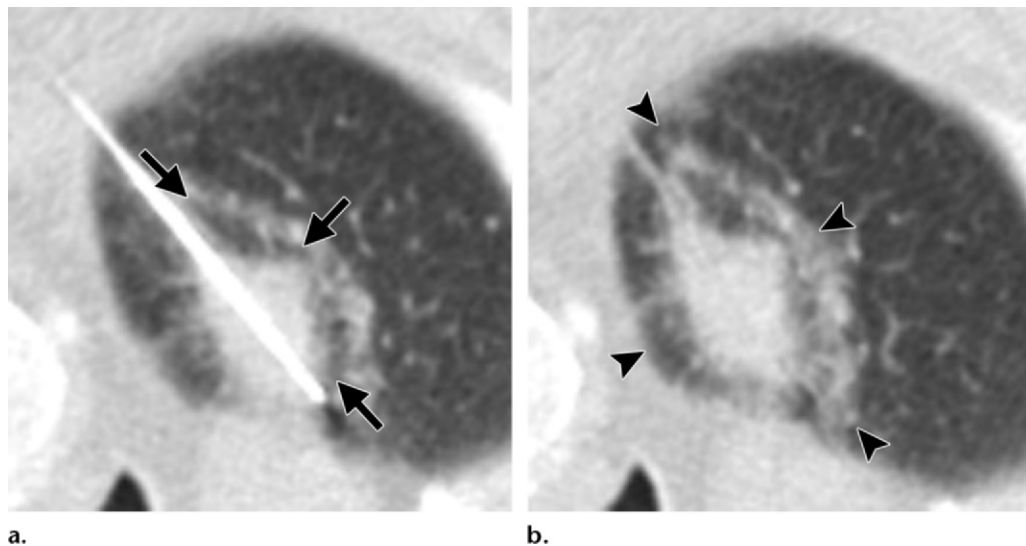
Metastatic ependymoma in a 58-year-old man undergoing RFA with a single probe. (a) CT image obtained at completion of the ablation cycle shows increased attenuation around the probe and the lesion, a finding referred to as the lightbulb sign (arrows). (b) CT image obtained immediately after ablation and removal of the probe shows an area of cone-shaped sectorial hyperemia (arrowheads), a finding that corresponds to the safety zone, the area of ablation beyond the margins of the tumor.
